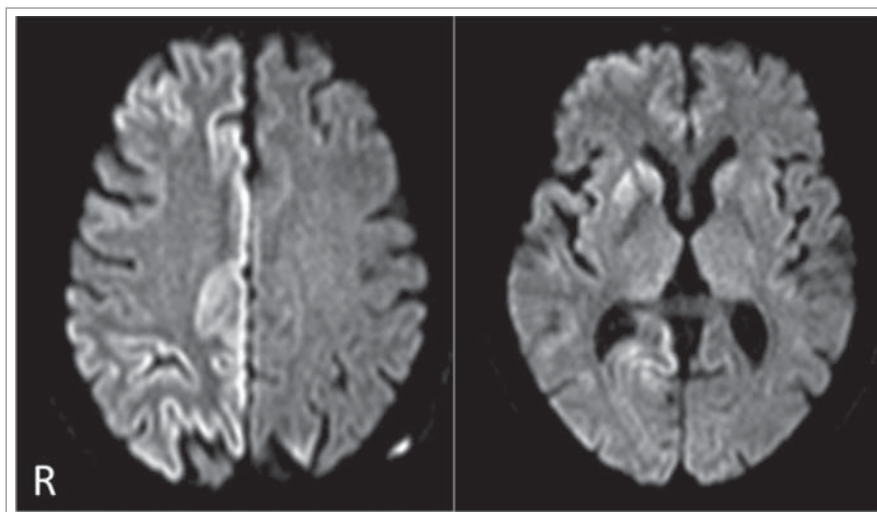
Diffusion-weighted magnetic resonance images showing increased signal intensity in the right basal ganglia and the right frontal, parietal, and occipital cortices.
